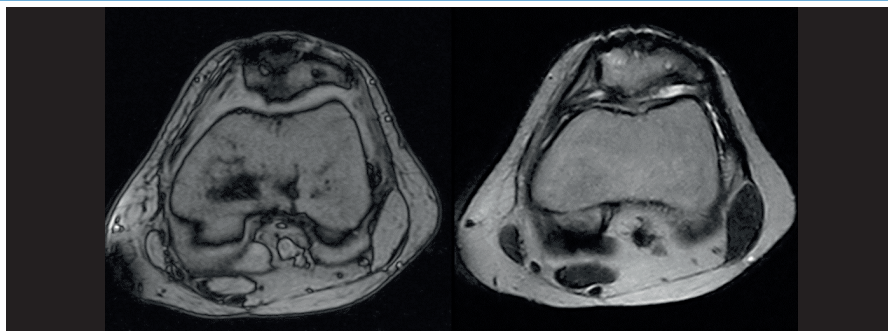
MRI 16 months after the trauma. One notes damage of the cartilage of the patella and a few indications of initial osteonecrosis of the trabecular bones of the knee.
